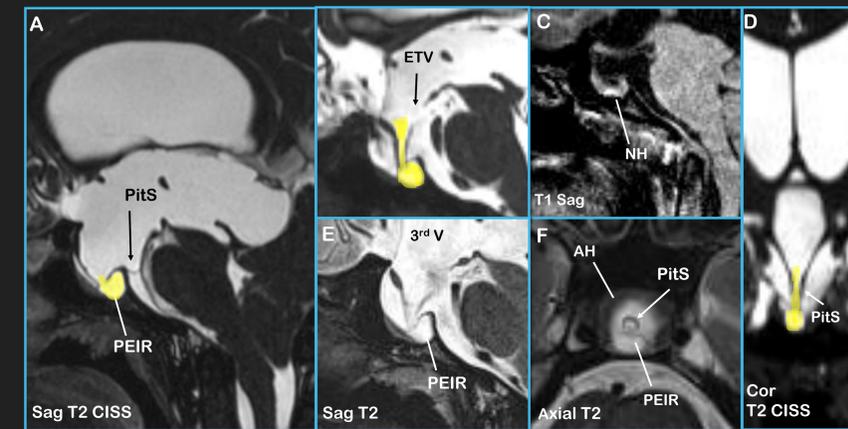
(A) MRI prior to endoscopic third ventriculostomy (ETV). Sag T2 CISS demonstrates aqueductal stenosis, severe ventriculomegaly with downward displacement of the floor of the third ventricle, and pituitary stalk. There is dilation of the infundibular recess, extending as a cystic dilatation into the sella, compatible with a PEIR. There is also tonsillar herniation/ Chiari 1 anomaly with horizontal orientation of a foreshortened clivus. Follow-up MRI was obtained 2-days later after ETV. (B,D,F) After decompression of the ventricles, high resolution T2WI demonstrates the persisting embryonal infundibular recess connecting the third ventricle and the sella more clearly. Note the expanded appearance of the sella with osseous remodeling on the sagittal images. (C) Sagittal T1WI shows the posterior pituitary T1 bright spot surrounding the recess of CSF within the sella, delineating a PEIR from pars intermedia cyst.
